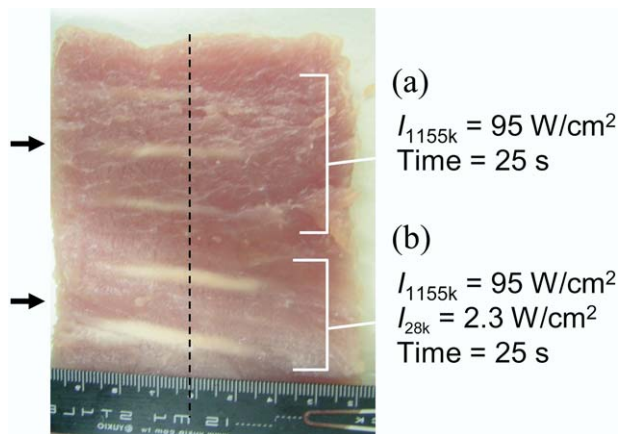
Comparison of the thermal lesions generated in two conditions: (a) 95 W/cm^2 , 1155-kHz ultrasound alone; and (b) combined 95 W/cm^2 , 1155-kHz and 2.3 W/cm^2 , 28-kHz ultrasound. In both cases the exposure time was 25 s. Vertical dashed line indicates the focal depth of the 566-kHz transducer.
